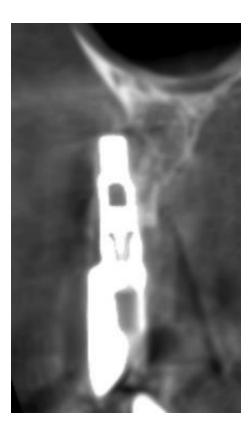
CBCT image at baseline prior to STE
